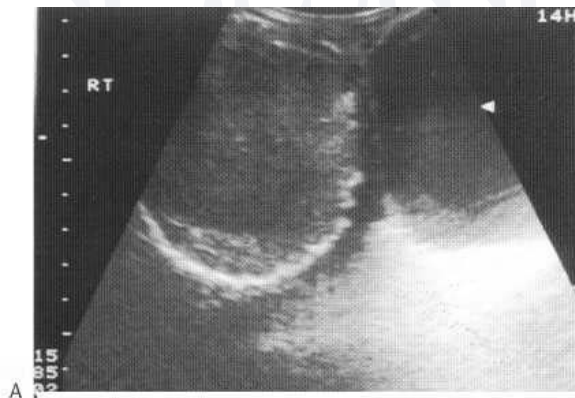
Ultrasound (A) showing dense peripheral calcification around the exterior of a chronic inflammatory hydrocele. This is also visible on the plain film (B).
